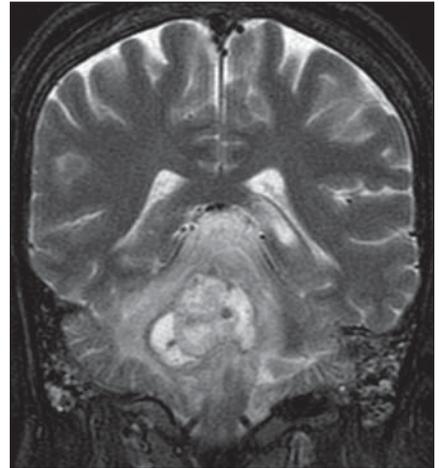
Coronal MRI T2-weighted sequence demonstrating heterogeneous hypersignal of the posterior fossa contents, with foci of marked hyposignal (air/gas) and hyperintense fluid in peripheral areas. Also, signs of bilateral mastoidopathy can be observed.
